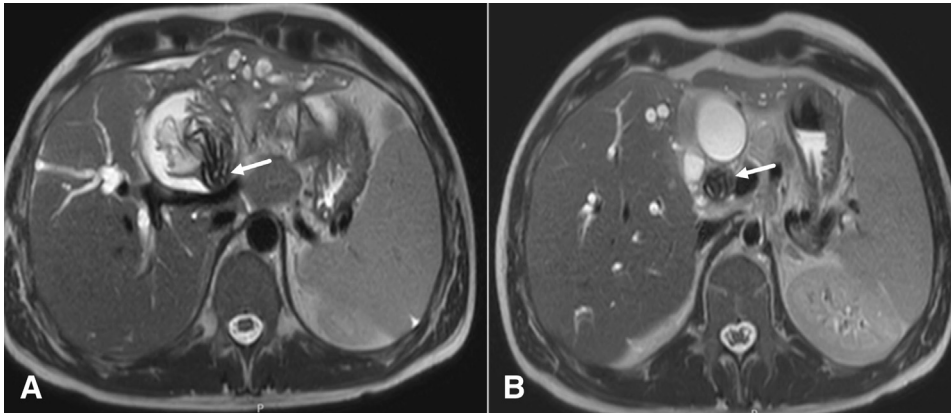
Consecutive axial T2-weighted fast spin-echo magnetic resonance images (A, B) show cyst rupture into the common hepatic duct and hydatid cyst membranes in the common bile duct (white arrows).
